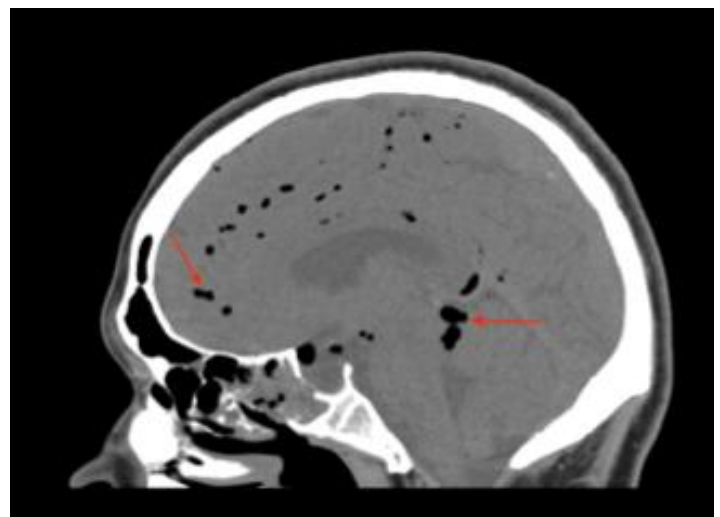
Sagittal view from head computed tomography without contrast demonstrating subarachnoid air. Red arrows indicate collections of hypoattenuation, representing air in the subarachnoid space.
